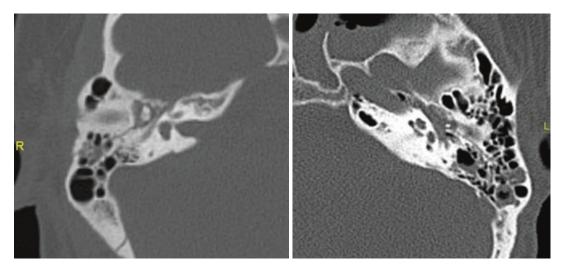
Axial CT sections of the temporal bones in two different patients (Right and Left) showing longitudinal fractures associated with hemotympanum and hemomastoid
